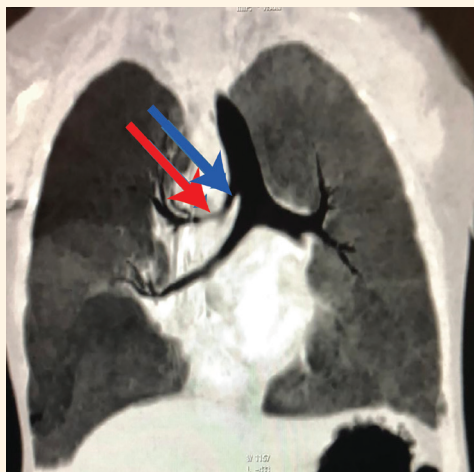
Pre-operative computed tomography scan of the chest of a 16-month-old girl showing the presence of an accessory bronchus (blue arrow) on the right side arising directly from the supracarinal trachea at a distance of 8-9 mm from the carina, suggestive of a tracheal bronchus. Entire right upper lobe is supplied by this accessory bronchus and there is marked focal thinning of the tracheal bronchus approximately 1 cm from its origin (red arrow). There is associated hyperinflation of the upper lobe of the right lung with paucity of the bronchovascular markings.
